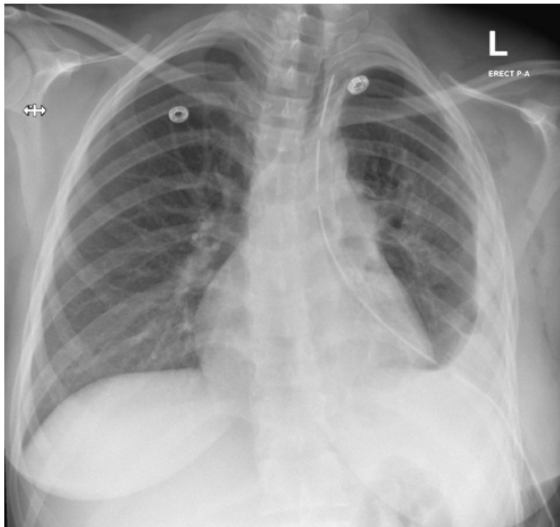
A chest X-ray showed a stable left apical chest drain, surgical emphysema in the left chest wall, and left pleural effusion
